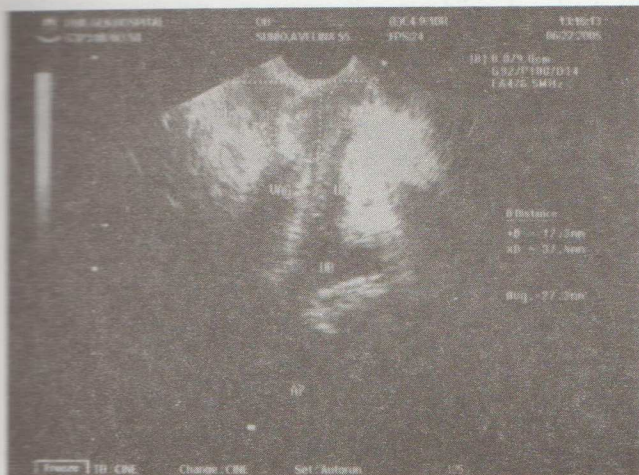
Transvaginal ultrasound demonstrating involvement up to 3.7 cm of the lower end of the vagina with encroachment into the posterior outlet of the urethra.
